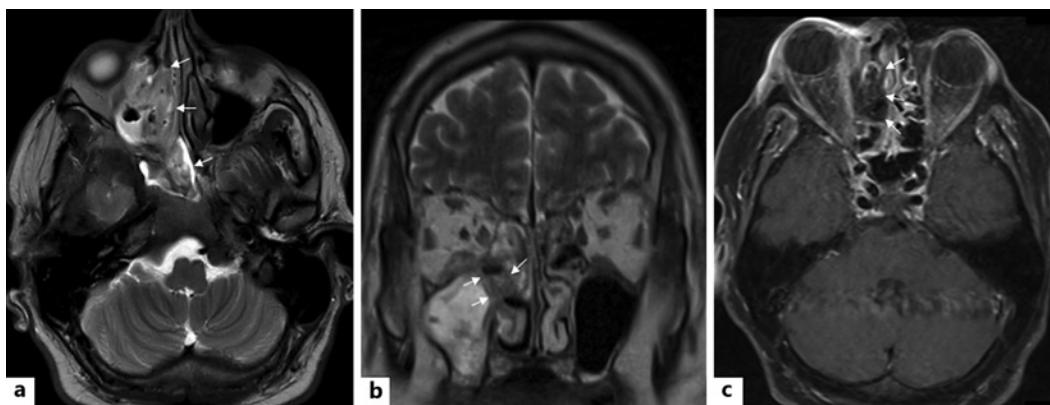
Patient 2: initial clinical examination and initial in-house MR scan. Due to the patient's pronounced movement, the scan is slightly superimposed by artifacts. Axial (a) and coronal (b) T2-weighted (T2w) images revealed extensive hypointense mucoid retentions on the right paranasal sinus (white arrows) with complete obliteration of the maxillary, ethmoid, and sphenoid sinus. c These mucoid retentions are without enhancement on the T1-weighted (T1w) post-contrast phase (white arrows) thus demonstrating the "black turbinate sign" indicative of angioinvasive fungal sinusitis.
